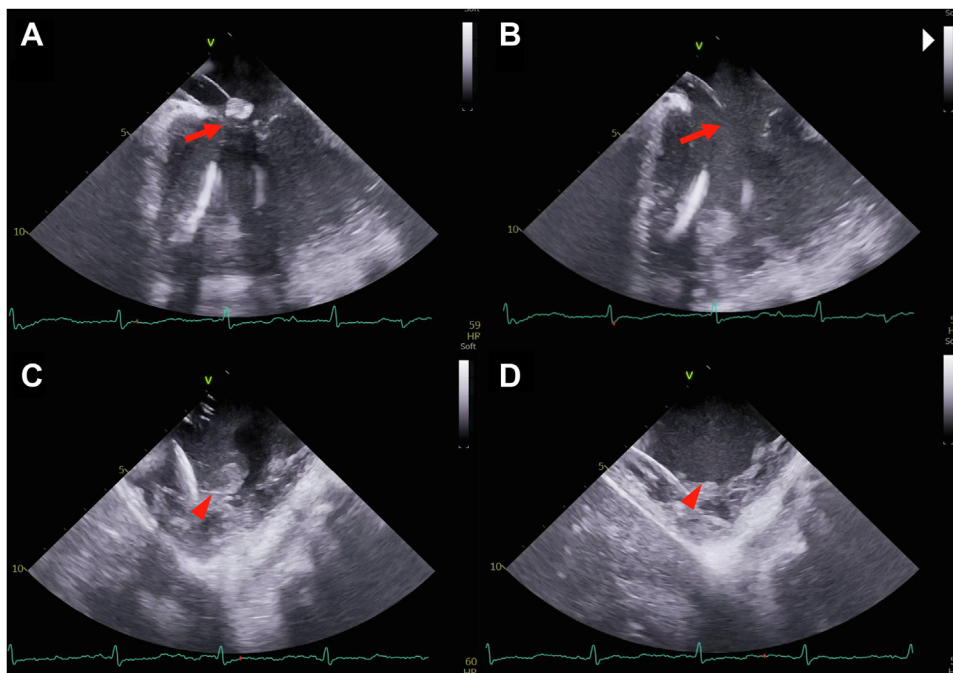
Intraprocedural intracardiac echocardiography (ICE). A: ICE image of echogenic mass (arrow) attached to the tricuspid valve with Penumbra Lightning aspiration system (Penumbra Inc) directly above it. B: After aspiration the vegetation is no longer present. C,D: Similarly, a right ventricular mass (arrowhead) is seen before (C) and after aspiration (D).
